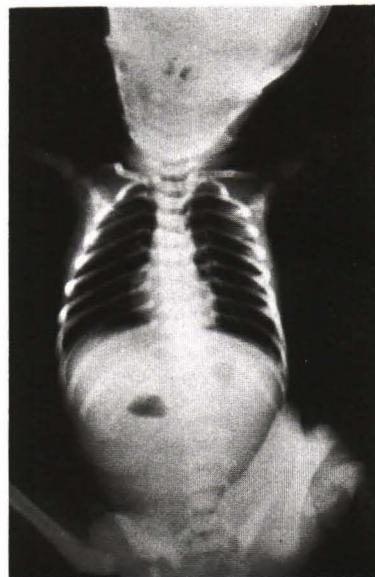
Plain upright radiograph of the infant in case 1 shows double bubble appearance.
